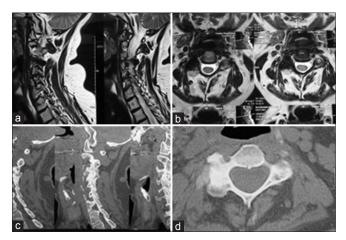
(a) MRI sagittal section with hypointense lesion at the level of C 2-3; (b) MRI axial section at the level of C 2-3 with Hypointense lesion and right sided compression on the spinal cord; (c) Sagittal CT scan of cervical spine with C 2-3 facet joint lesion; (d) Axial CT of Cervical spine with right sided expansile sclerotic lesion at C 2-3
